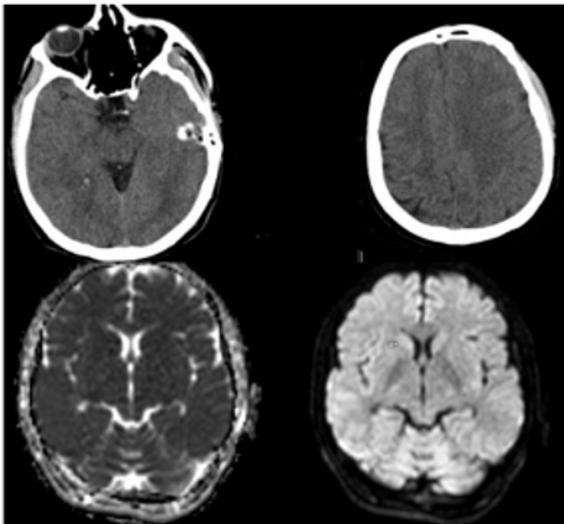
CT and MRI images of the patient within normal limits.
